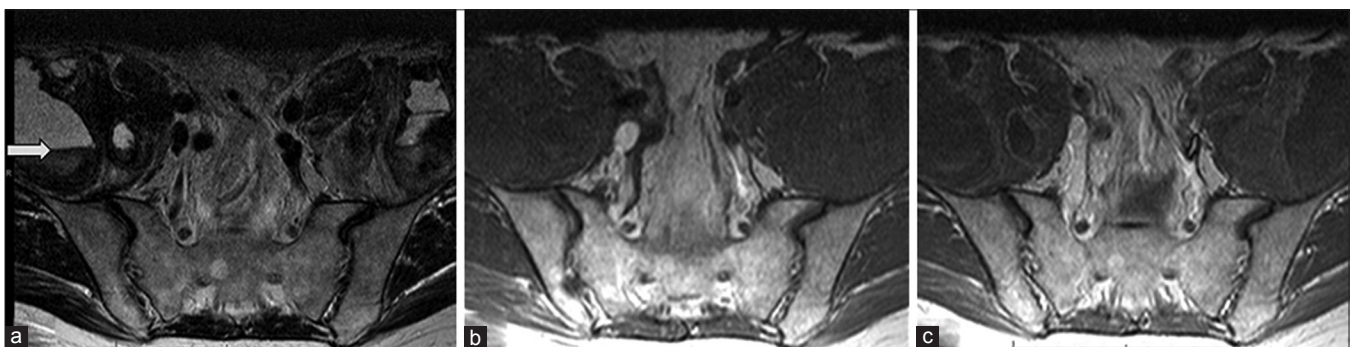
(a) Axial T2, (b) precontrast T1, and (c) postcontrast T1-weighted axial MR images of the lumbar spine showing markedly enlarged bilateral iliac muscles containing heterogeneous hematomas, which also show fluid–fluid level on axial T2-weighted images
